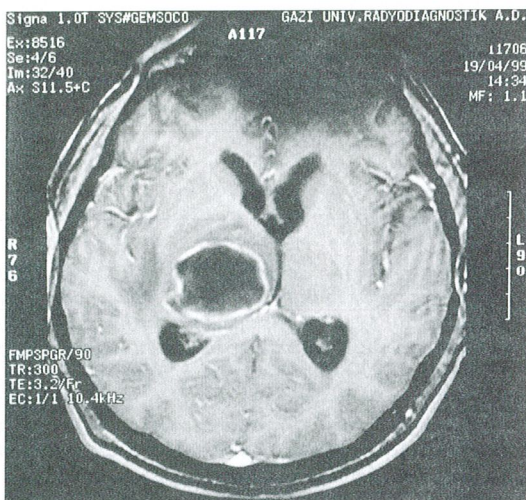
Right thalamic cystic lesion showing marked surrounding enhancement after infusion of contrast agent on axial T-1 weighted MRI.
